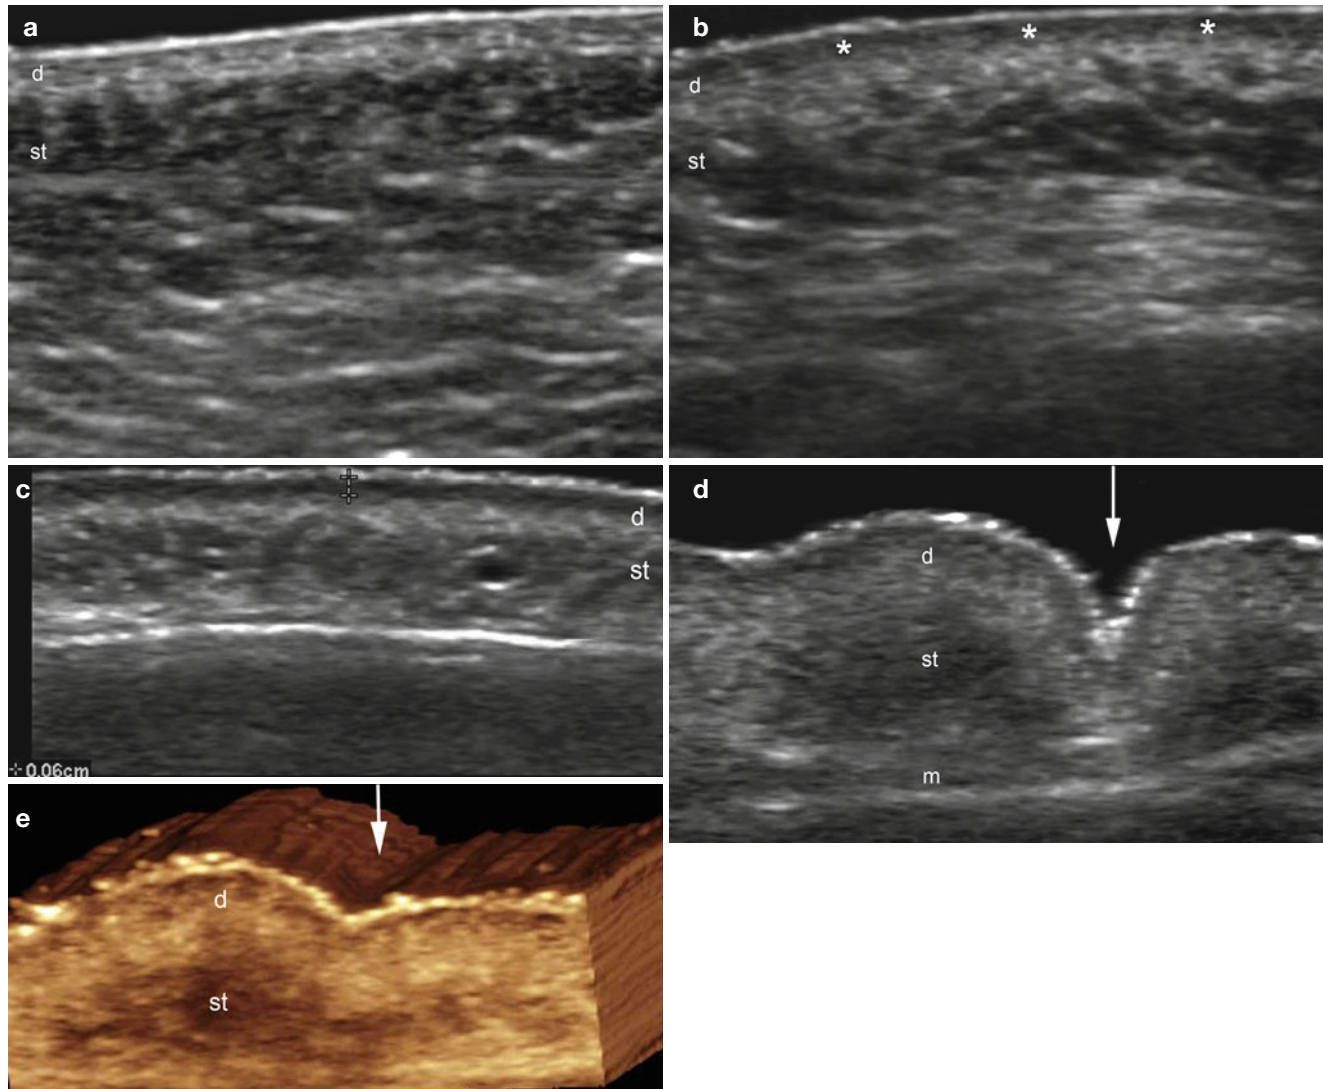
(a–e) Photoaging. (a) The skin of a 1-year-old child (grey scale ultrasound image, transverse view, right cheek). (b) The skin of a 50-year-old, sun-exposed woman (grey scale ultrasound image, transverse view, right cheek). Notice the decreased echogenicity band in the upper dermis (in comparison with Fig. a) that corresponds to elastosis (*, subepidermal low echogenicity band-SLEB). (c) Grey scale ultrasound
